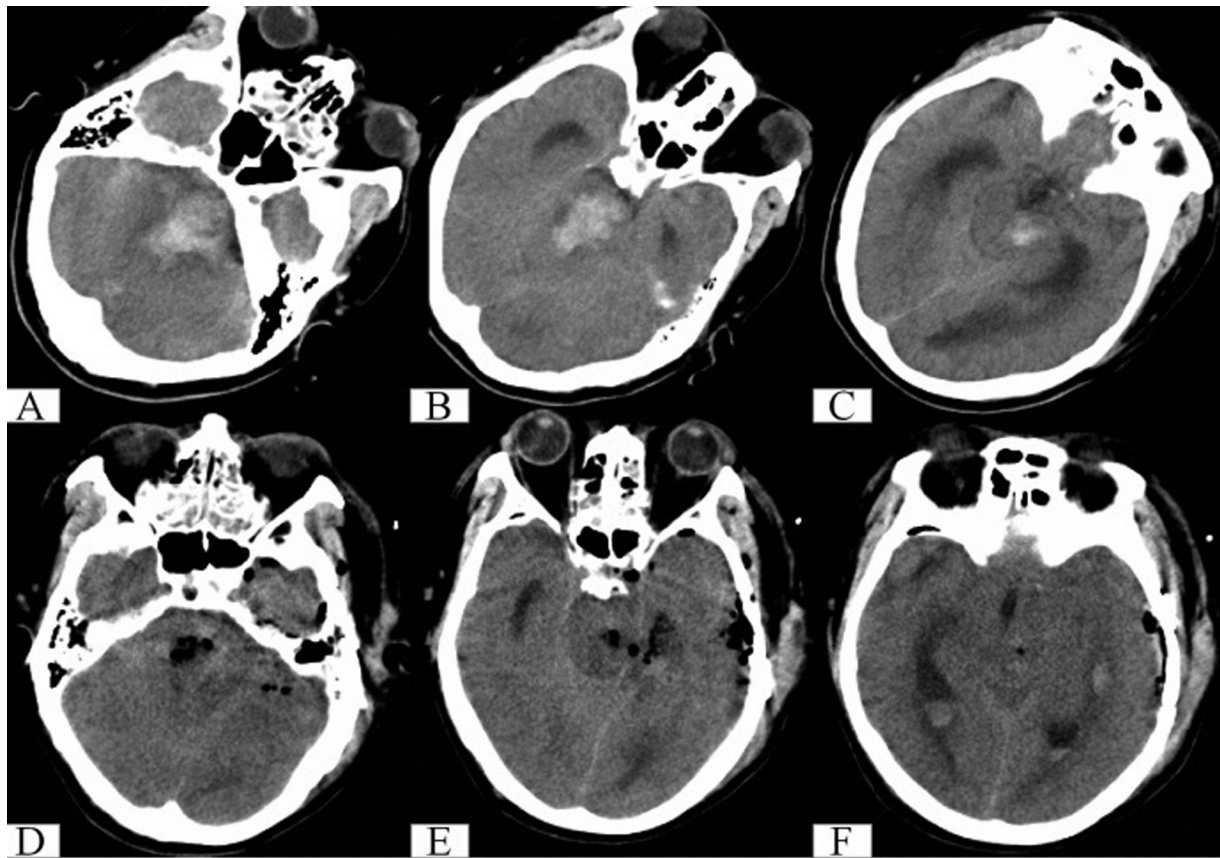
Representative male, 53 years of age with a GCS score of 6 on admission. (A–C) A head CT demonstrated a “massive” pons hemorrhage extending into the midbrain combined with hydrocephalus. The hematoma volume was ~11.0 mL. Ventricular external drainage was initially performed before the craniotomy and most of the hematoma was removed through the left subtemporal tentorial 31 hours after onset of the first symptom. (D–F) A postoperative CT shows that ~95.5% of the hematoma was removed. Even though the hematoma was removed, the patient passed away due to brainstem function failure 10 days after surgery. CT, computed tomography; GCS, Glasgow Coma Scale.
